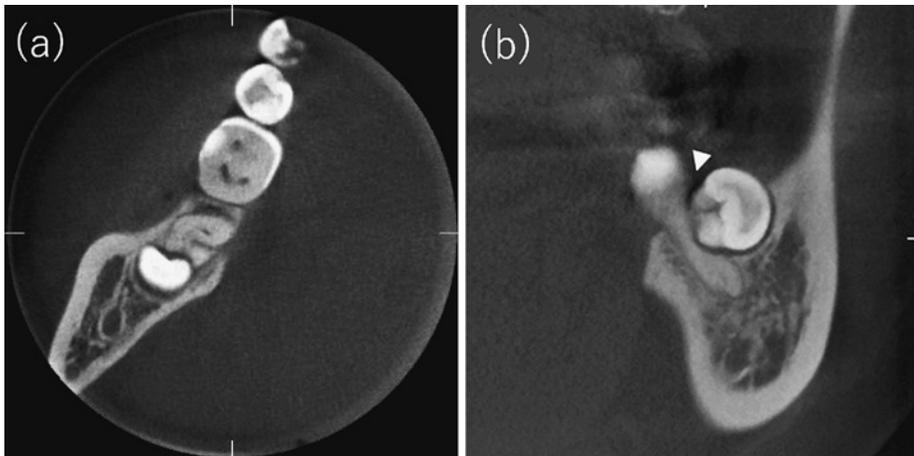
Cone-beam computed tomography images
